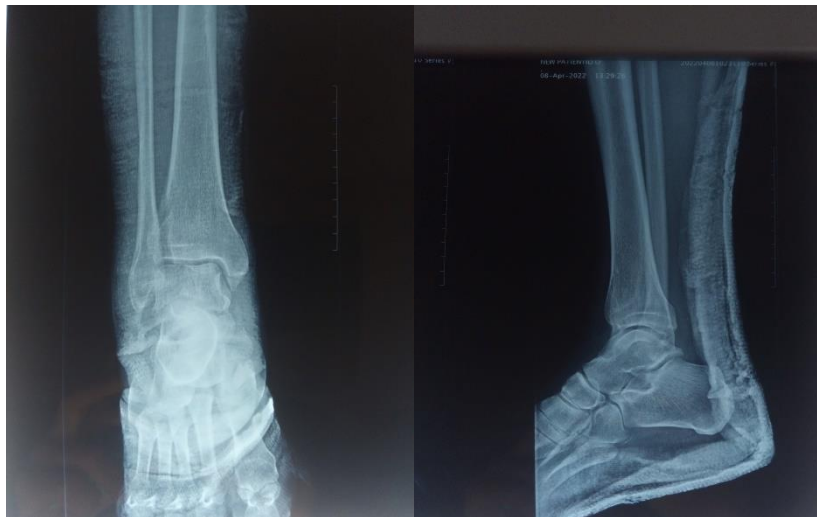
X-ray after reduction with posterior plaster splint.
